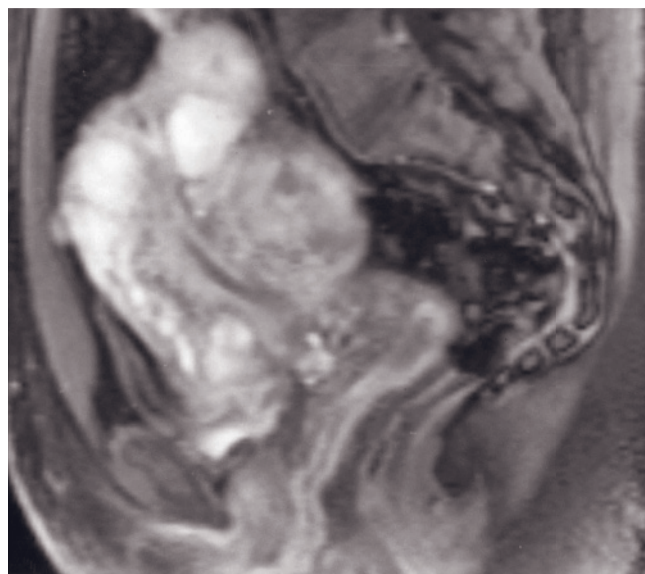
Prolapsed submucosal leiomyoma. Sagittal T2-weighted (*a*) and gadolinium-enhanced fat-suppressed T1-weighted (*b*) images show a large mass (m, *a*, *b*) arising from the uterine wall, anterior to the endometrial stripe (arrowheads, *a*). The mass extends through the cervix into the vagina. At surgery, the cervix was found to be dilated 10 cm to accommodate the leiomyoma. Note the nabothian cyst, which identifies the posterior aspect of the dilated cervix (arrow, *a*, *b*).
